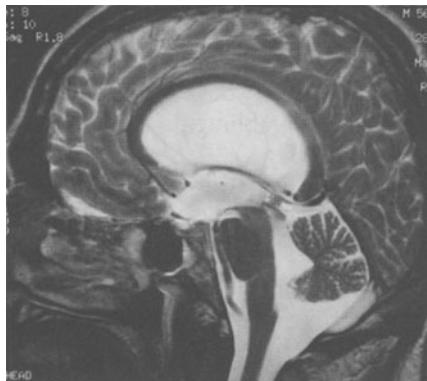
This midsagittal MRI shows how close the basilar artery can be to the dorsum sellae. Performing an ETV would be relatively dangerous
